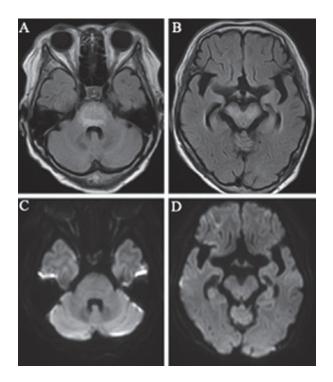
(A) Brain MRI showing mildly swollen pons, and inhomogeneous hyperintensities that mainly involved pontine longitudinal fasciculus and transverse pontine fibers on FLAIR imaging. (B) Brain MRI showing inhomogeneous hyperintensities in cerebral peduncle, but no abnormalities in the supratentorial area on FLAIR imaging. (C) (D) No abnormalities are shown on DWI.
